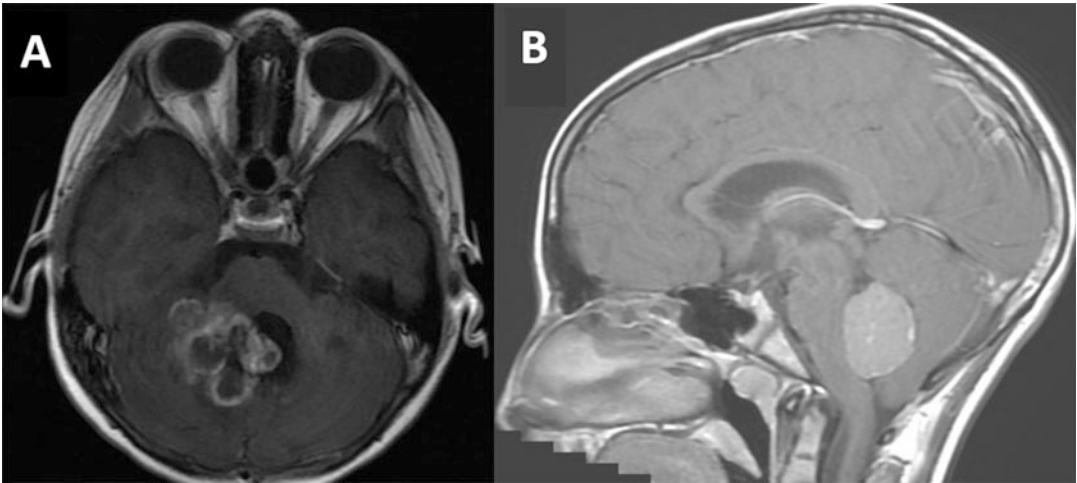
(a) Axial brain MRI T1WI with contrast showing an irregularly enhancing posterior fossa fourth ventricular lesion in a child with recurrent ependymoma with spinal metastases. (b) Sagittal T1WI+C of a
